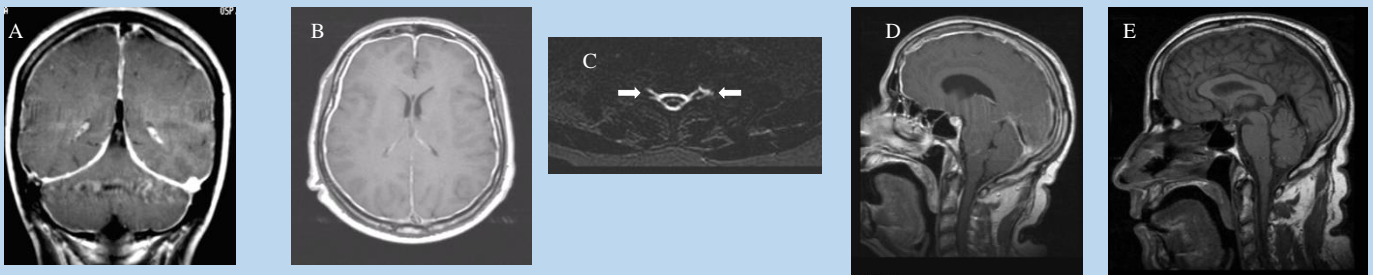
A-B: Brain MRI shows diffuse pachymeningeal enhancement
